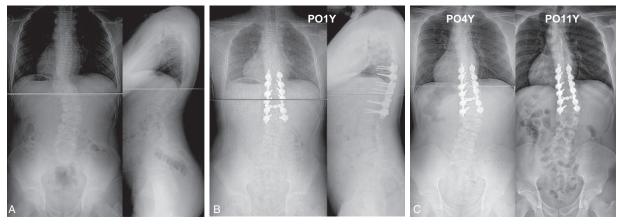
(A) A 13-year-old male who had congenital hemivertebra of T11 with 41° of left thoraco-lumbar main curve. (B) Postoperative 1-year follow-up radiographs showed that the main curve improved to 10° . (C) Four years and 10 years follow-up radiographs showed that distal lumbar curve somewhat progressed during follow-up period with treatment by brace.
